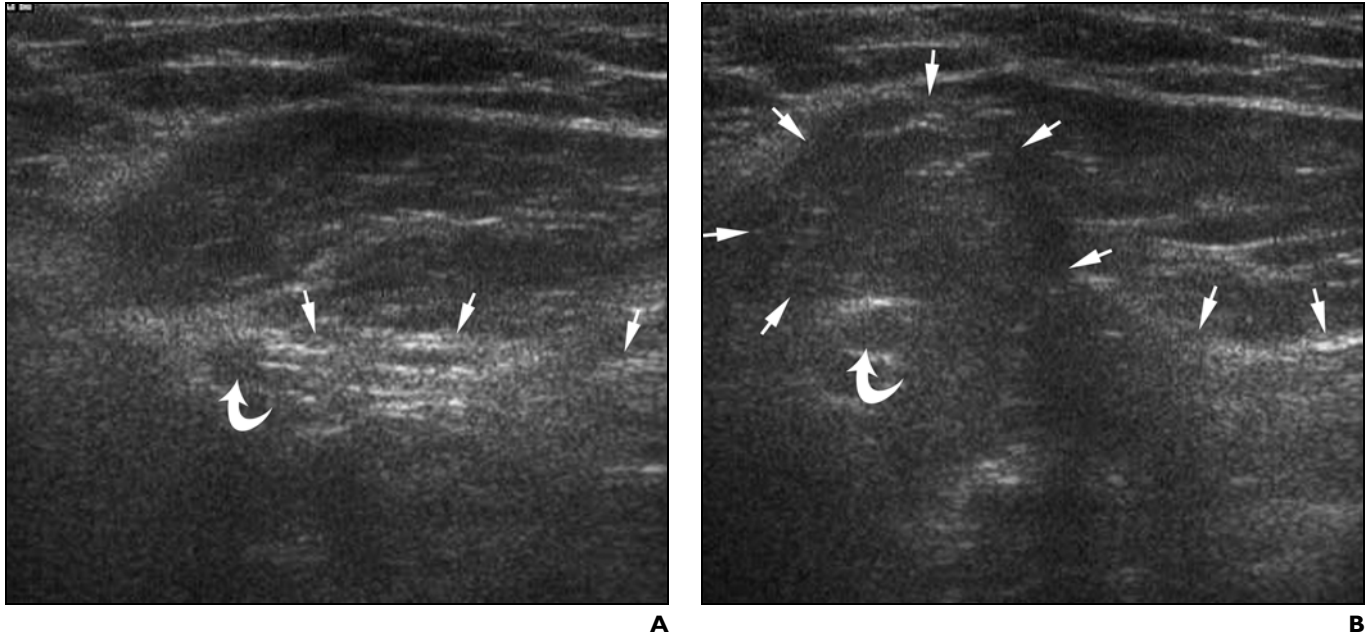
39-year-old man with direct inguinal hernia. Sonogram of right inguinal region parallel to and cranial to inguinal ligament corresponding to transducer position 3 in Figure 4.
